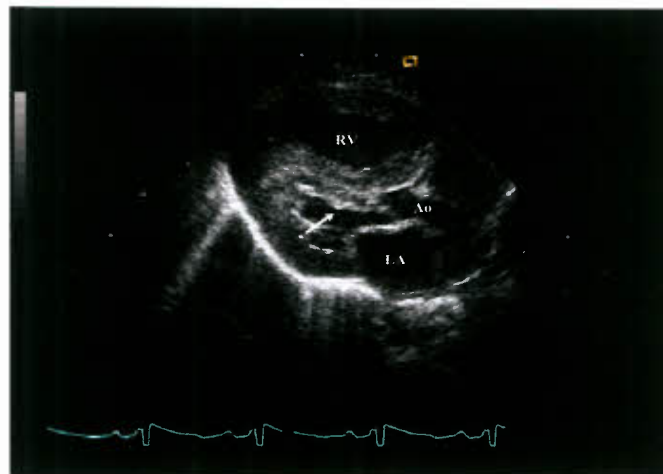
Parasternal long-axis view in a patient with HLHS. The left ventricular chamber is small and muscle bound. The endocardial surface of the LV is echobright, consistent with endocardial fibroelastosis (arrow). Ao, aorta; LA, left atrium; RV, right ventricle.
